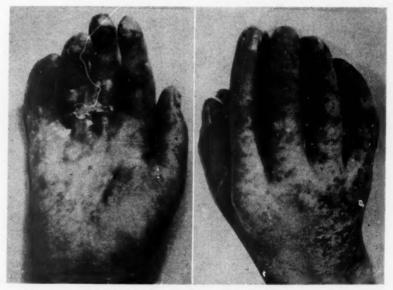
Roentgen dermatitis of two years' duration following two treatments for fungus infection. Hand amputated (elsewhere) at insistence of patient.
